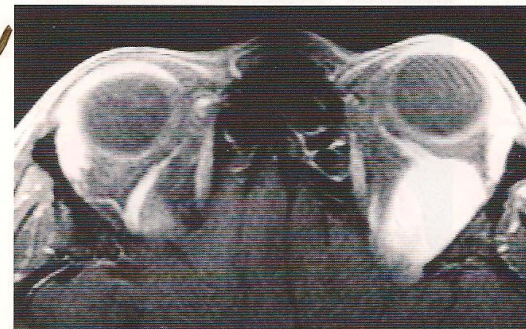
Axial magnetic resonance imaging during Valsalva maneuver demonstrated the mass.
